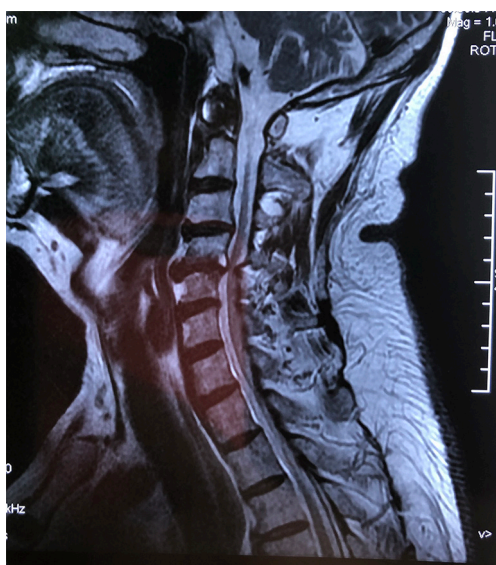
The magnetic resonance imaging of case 3 demonstrated the presence of severe spinal compression in C4/5.
